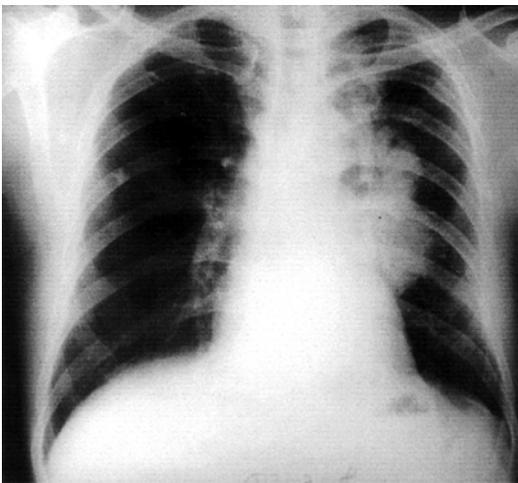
52-year-old man with pulmonary inflammatory pseudotumor. The chest radiograph showed a huge mass-like density in the left upper and lower lung fields.
